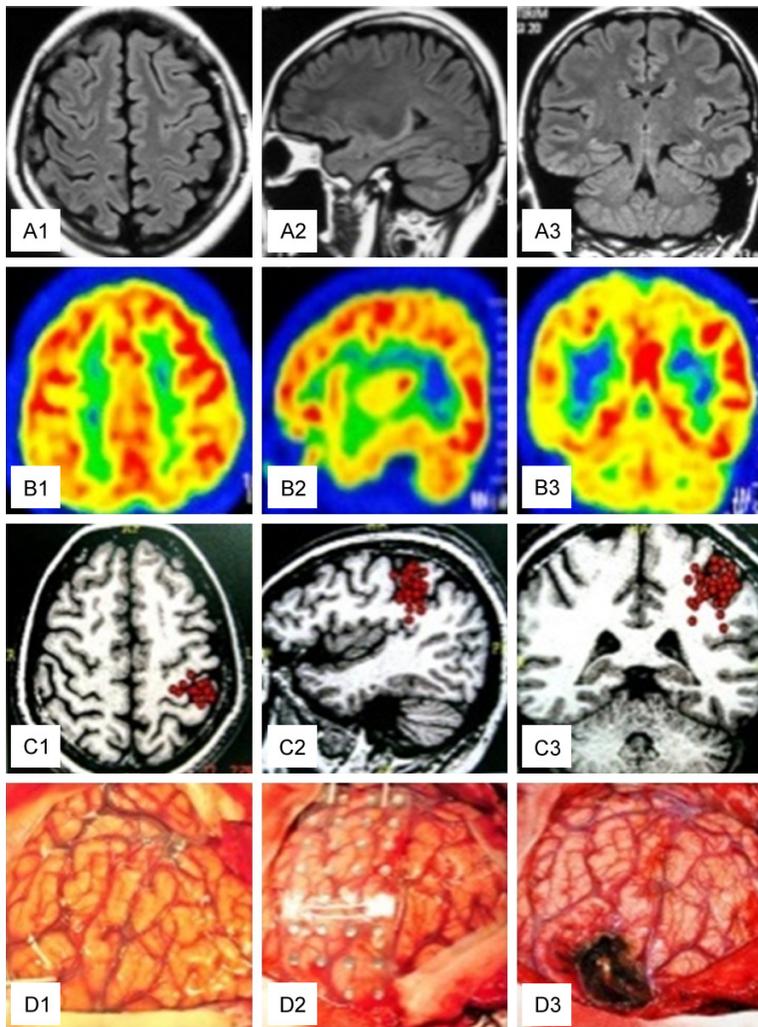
A. Lesions in the left parietal lobe were absent in the axial (A1), sagittal (A2), and coronal (A3) FLAIR sequences. B. Hypometabolism in the left parietal lobe is absent in the axial (B1), sagittal (B2), and coronal (B3) interictal FDG-PET scans. C. The epileptogenic foci were localized in the left central area in the axial (C1), sagittal (C2), and coronal (C3) interictal MEG (red dots). D. (D1) No abnormalities in the left parietal cortex. (D2) The results of invasive monitoring showed epileptogenic foci in the left central area. (D3) The non-functional cortex was removed and the central gyrus was coagulated.
